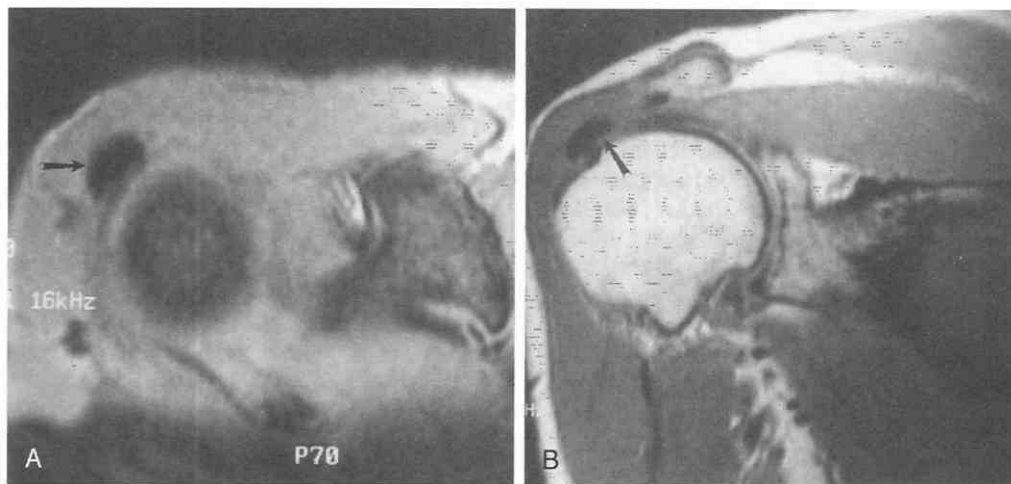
Calcific tendinitis. *A*, Gradient-echo axial image. A large area of signal void (arrow) is present near the attachment site of the supraspinatus tendon. *B*, Proton-density-weighted (TR = 2500 msec, TE = 14 msec) coronal oblique image. Signal void is present in the relatively avascular area of the supraspinatus tendon (arrow). This area was also dark on T2-weighted images. Calcium was apparent by plain films (not shown).
